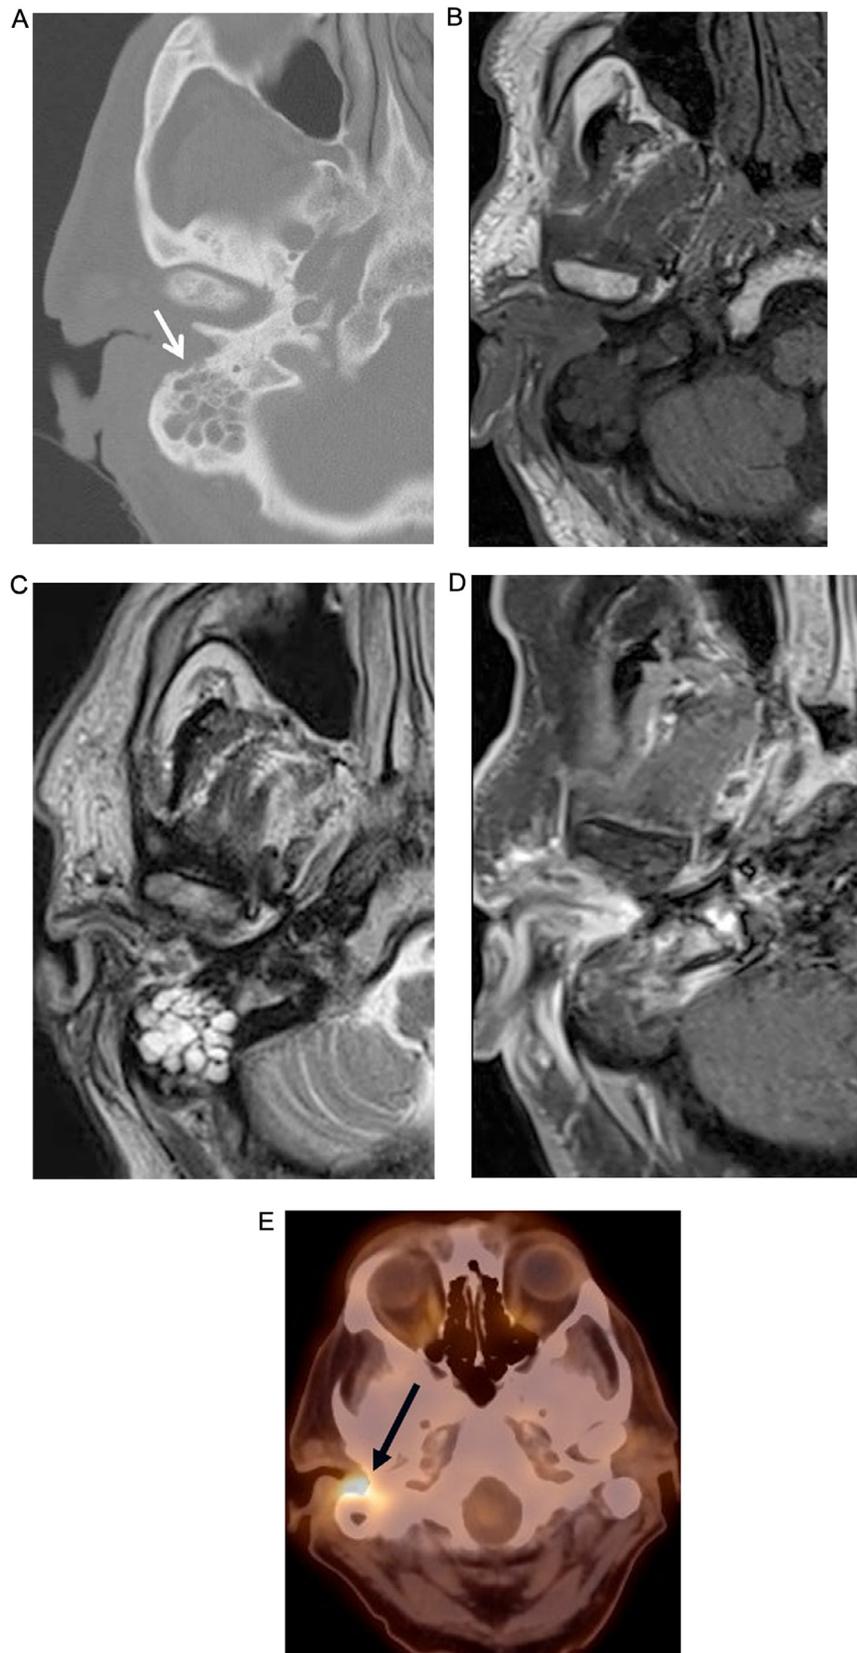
63 m h/o diabetes with pseudomonas infection. Axial CT image (A) shows soft tissue within the EAC with osseous erosion of the posterior wall of the EAC (arrow) not evident on axial T1W (B), T2W (C), or postcontrast T1W with fat saturation (D) images. FDG-PET/CT fused image (E) shows increased uptake (arrow).
